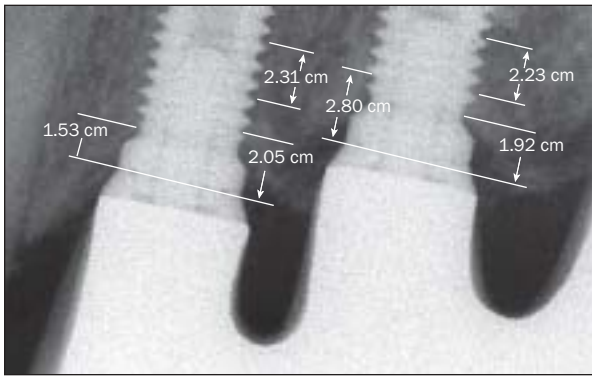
Assessment of the distance from the shoulder to the first bone-to-implant contact on digitized radiographs (original magnification $\times 12.5$). The known distance between 3 implant threads was used for calibration and determination of the exact magnification of the images.
